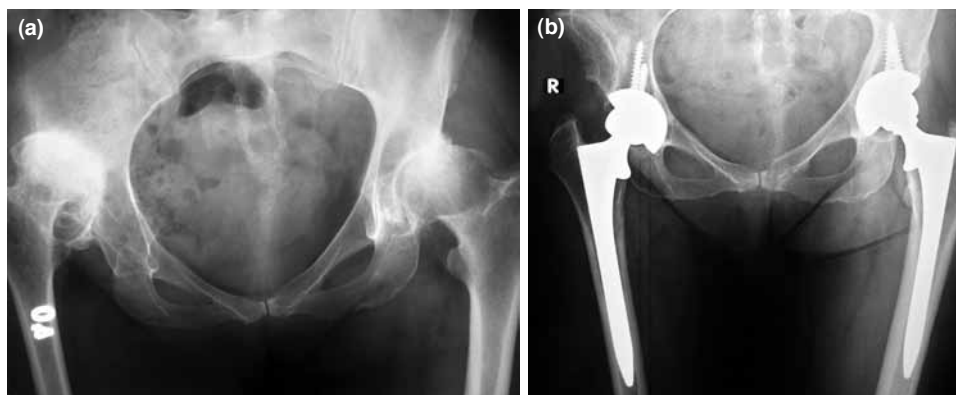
(a) Preoperative pelvic radiograph of a 62-years-old woman disabled from severe pain. (b) Bilateral staged total hip arthroplasty was performed with cementless, bi-coated components (postoperative 5th year follow-up radiogram).
